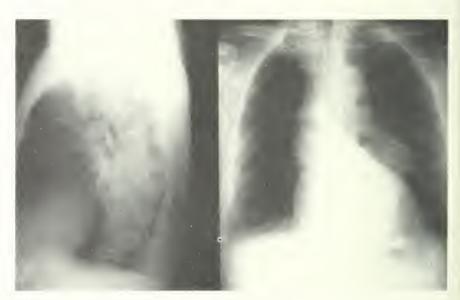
X-rays of chest day prior to admission show aneurysm of the descending thoracic aneurysm.
